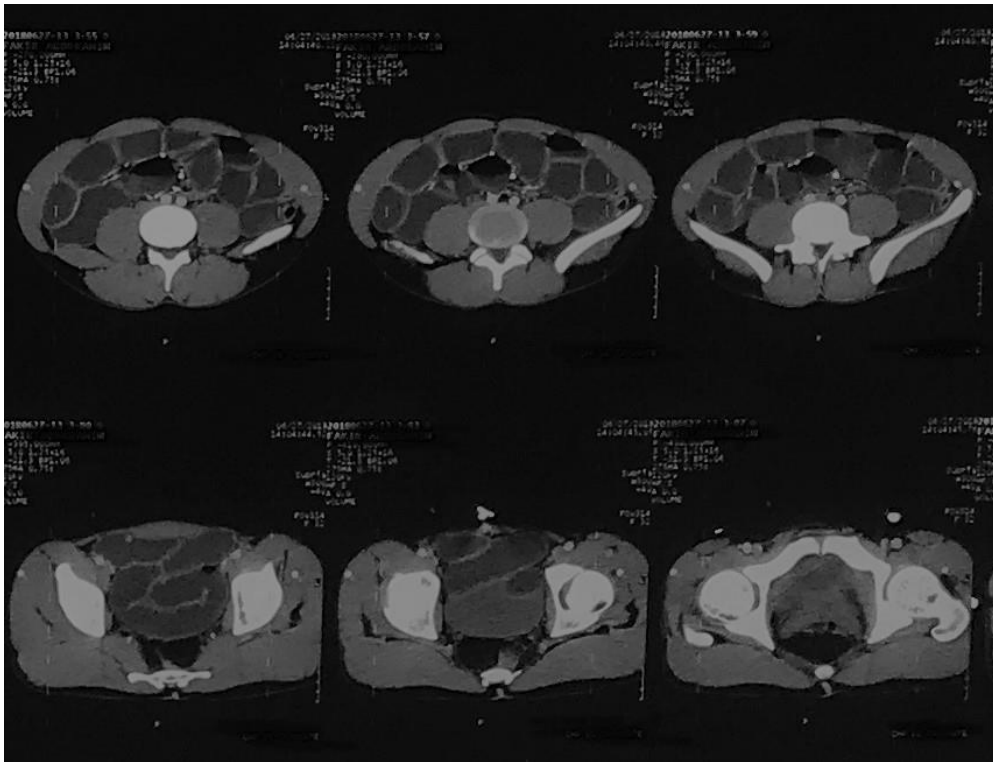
CT scan showed a small bowel obstruction due to dilated bowel loop compressing the bladder
